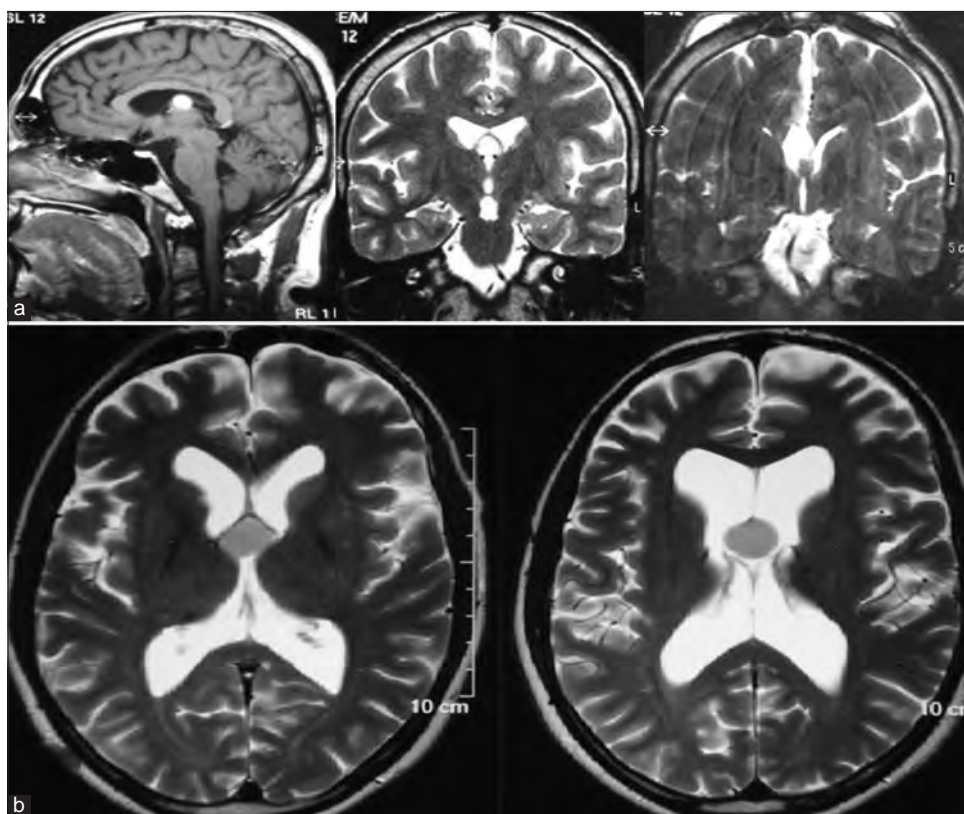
Transcalsal approach to the third ventricle. (a) Transcalsal transchoroidal approach – Plain T1-weighted sagittal, T2-weighted coronal, and post-operative T2-weighted coronal image showing complete excision of posterior third ventricular colloid cyst, which needed to be targeted with a transchoroidal approach. (b) Transseptal-interforniceal approach – midline colloid cyst located within the septal leaflets, optimally targeted with a transseptal-interforniceal approach
